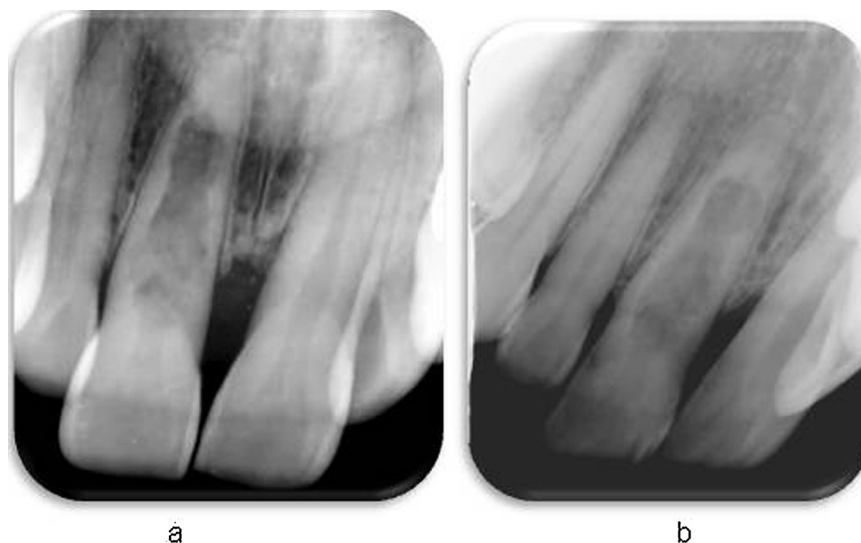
(a and b) Preoperative periapical angulation radiographs: extensive internal root resorption in maxillary right central incisor
